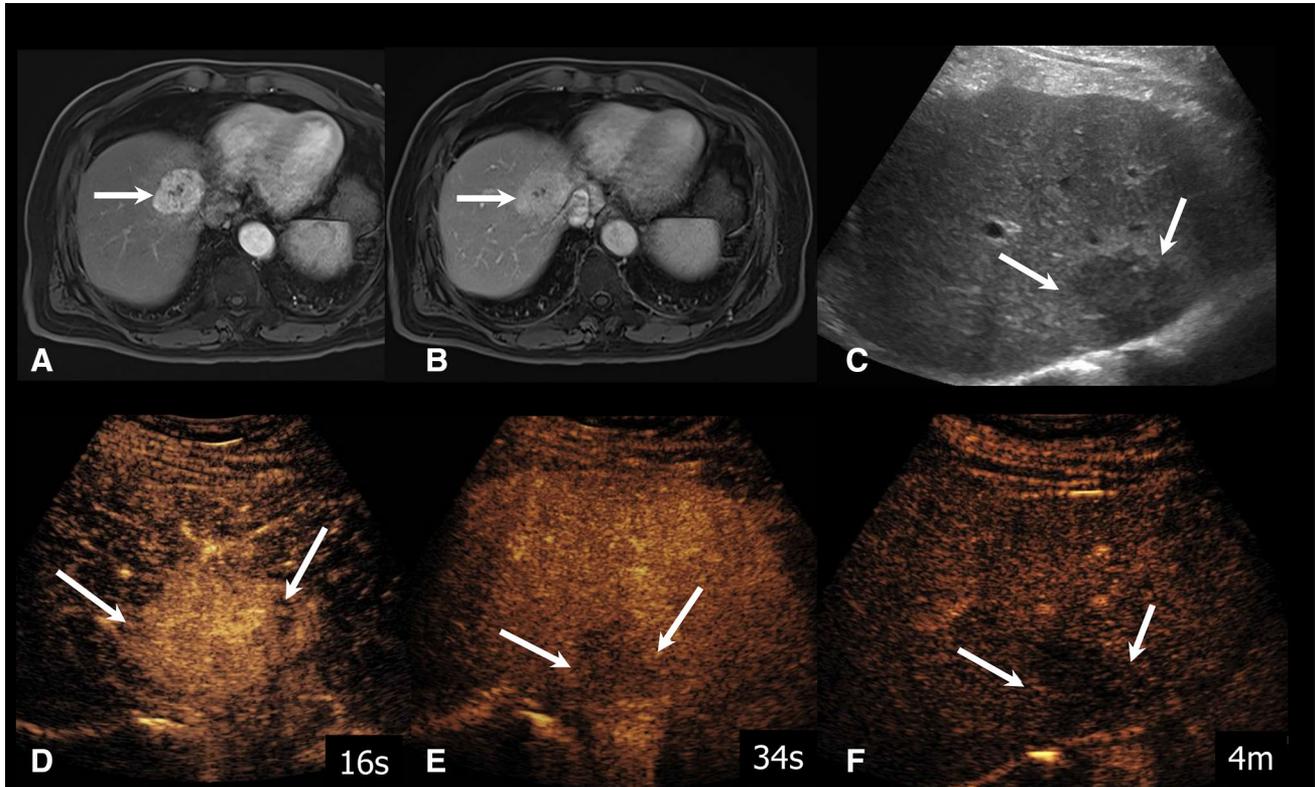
CEUS LR-M, probably or definitely malignant nodule, not specific for HCC. A 78-year-old male with HBV and a growing nodule on MR, previously diagnosed 2 years earlier on MR as a hemangioma. Post-gadolinium MR images in A the arterial phase (*arrow*) and B the portal venous phase show observation with arterial phase enhancement with no washout in either the portal venous or the delayed
